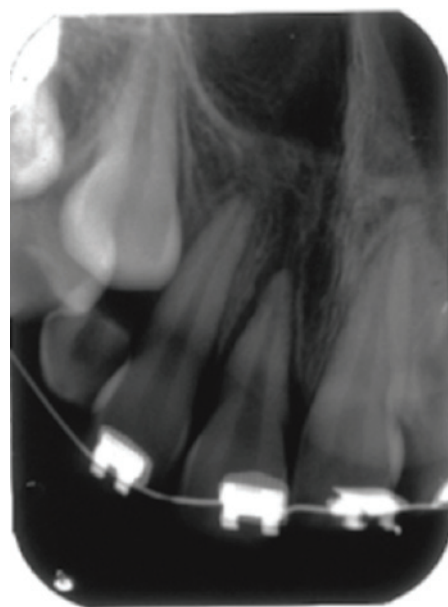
Periapical radiograph of the incisors after the accident.
